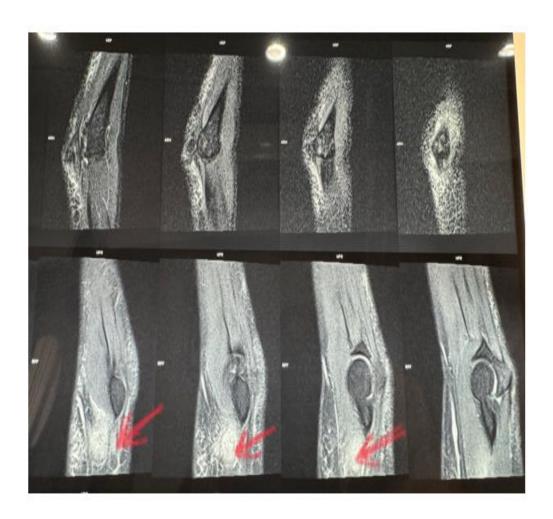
MRI of elbow. Arrow shows the collection/abscess.
